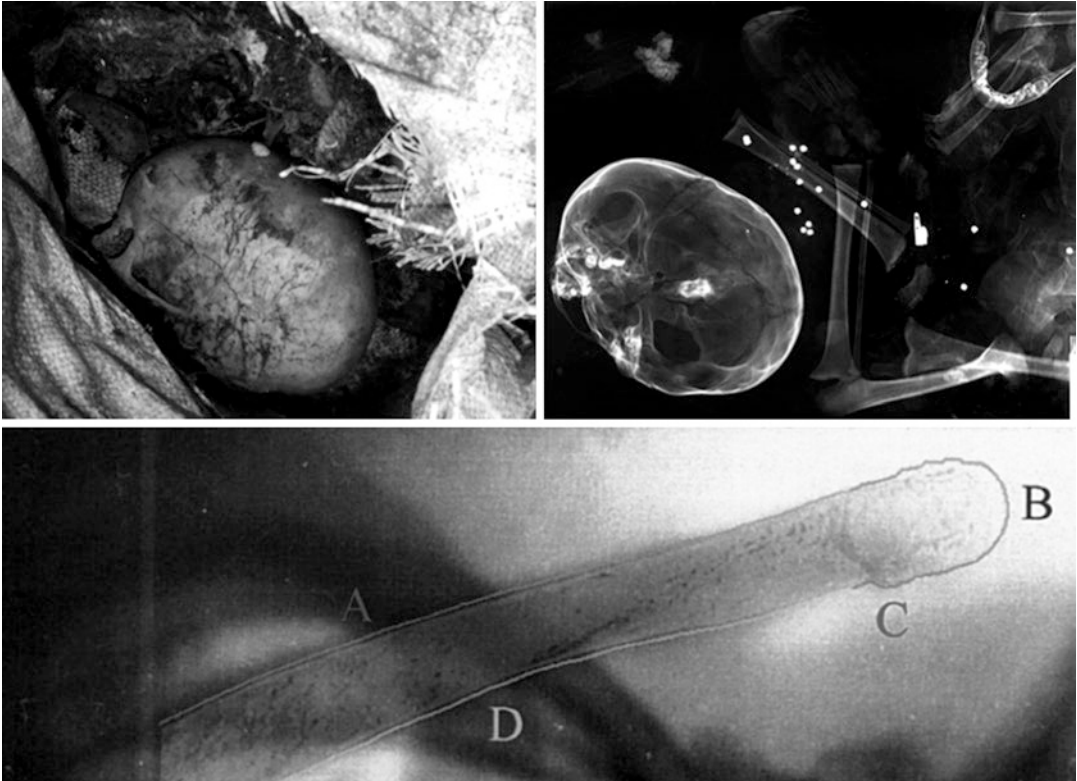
Personal identification performed through X-ray superimposition of the clavicle; the letters indicate the individualising anatomical features
